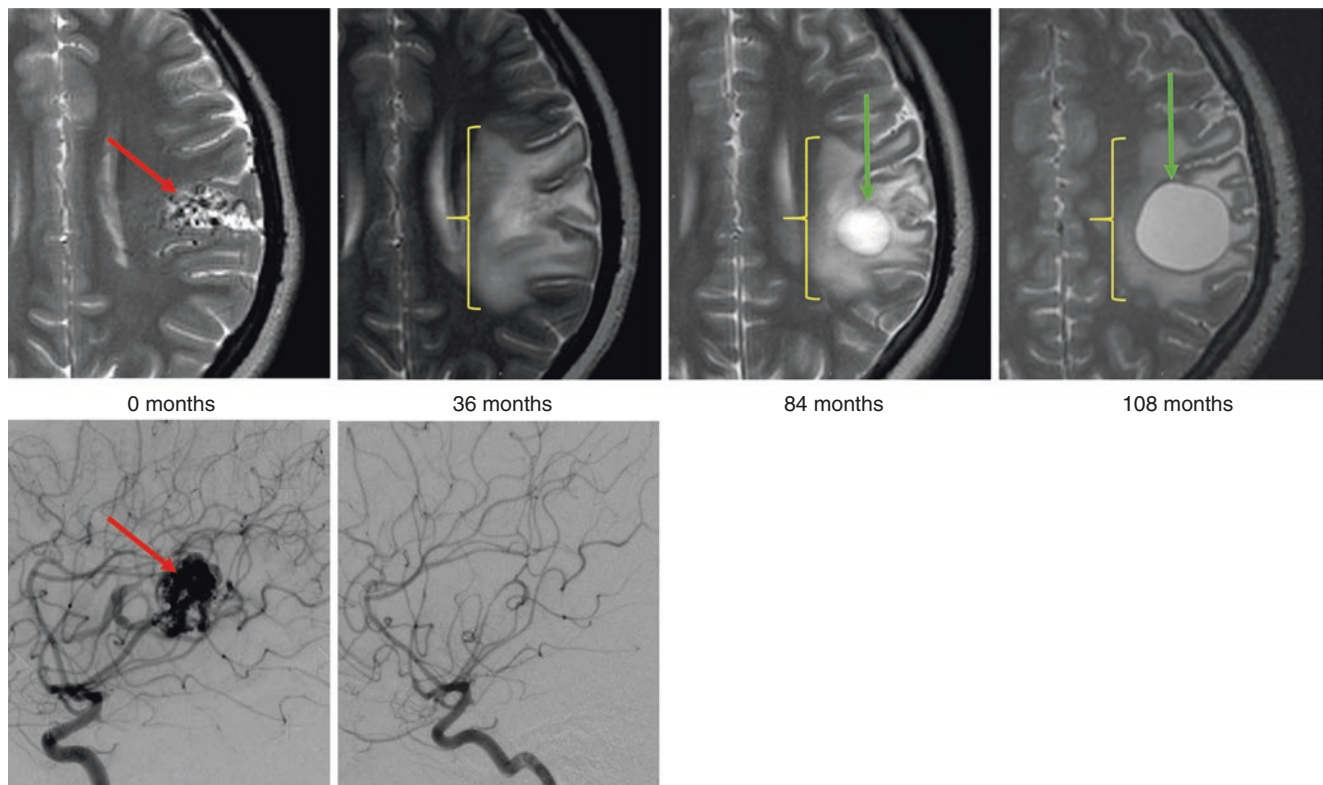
Arteriovenous malformation with intraparenchymal cyst formation. Axial T2-weighted MR images (top row) obtained at 0, 36, 84, and 108 months with corresponding left middle cerebral artery catheter angiogram (bottom row) at 0 and 36 months. At baseline pretreatment examination, the AVM nidus is seen as hypointense flow voids on the T2-weighted image within the lateral left frontal lobe and as a compact nidus on the catheter angiogram (red arrow). Note the absence of perinidal gliosis or edema at baseline examination. At 36 months, nidus
